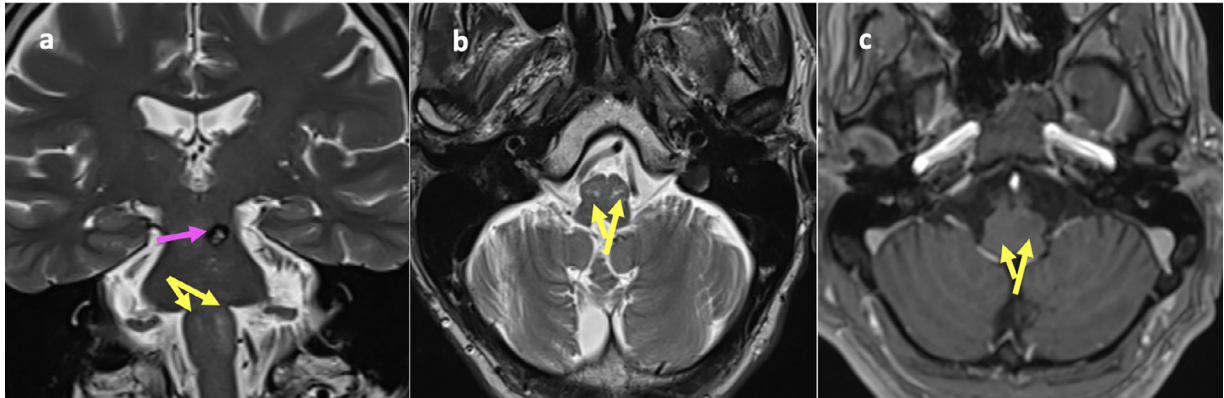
Brain-MRI images obtained more inferiorly on coronal (A) and axial (B) T2-weighted sections, and enhanced axial (C) section showed a bilateral enlargement of the olivary nuclei with high signal intensity, more pronounced on the left side, non-enhanced with contrast product (Yellow arrows), corresponding to bilateral hypertrophic olivary nuclei degeneration (HOD).
